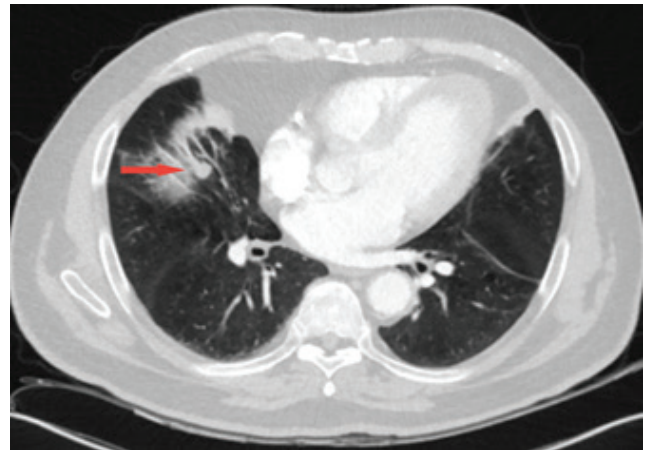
Preoperative chest computed tomography demonstrating a middle lobe pulmonary nodule (arrow).
